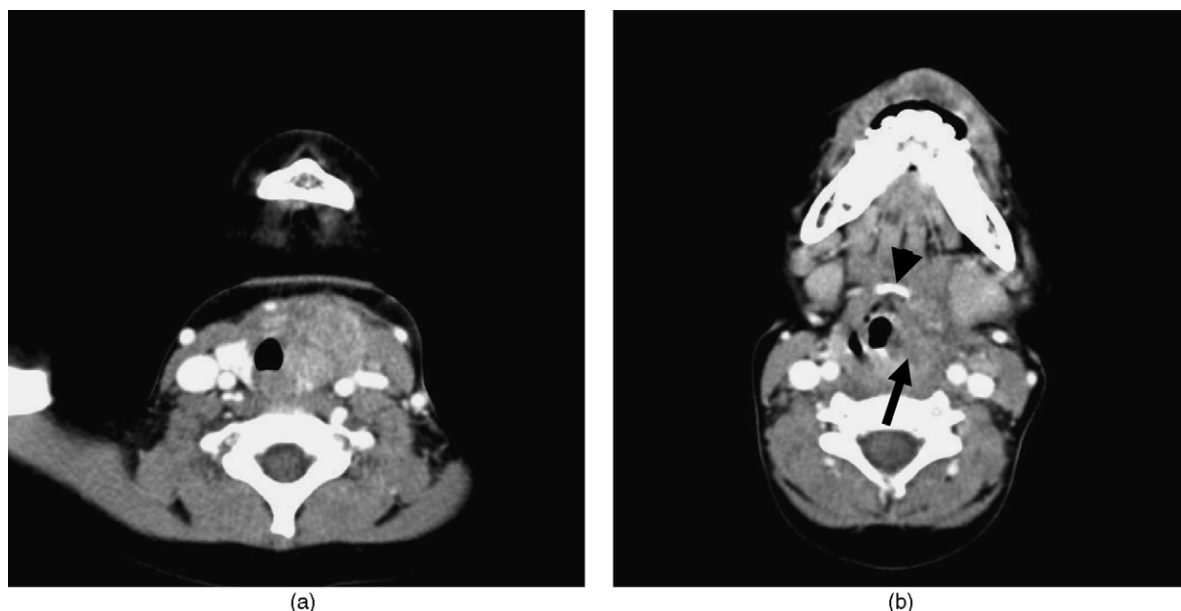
(a) Axial neck CT scan with contrast showing 3 cm × 3 cm enhancing soft tissue mass in anterior left neck involving left thyroid lobe with mass effect displacement of left sternocleidomastoid muscle and trachea, and with infiltration of adjacent subcutaneous fat. (b) Axial neck CT scan with contrast showing superior extent of mass (arrow) at the level of the hyoid bone (arrow head).
